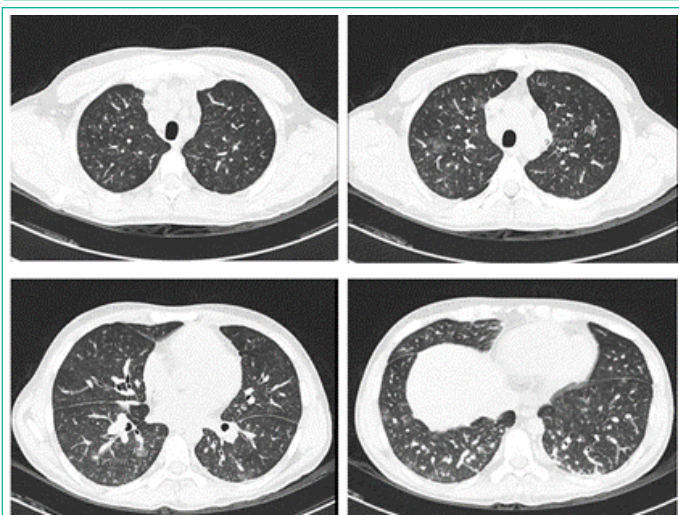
Chest computed tomography on day four of treatment.
